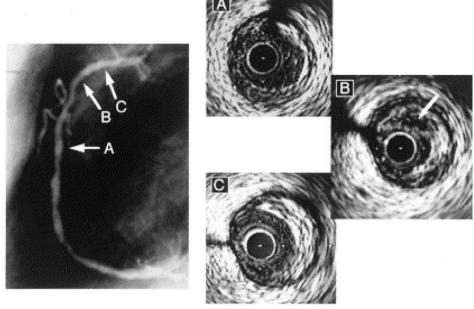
Coronary plaque in the right coronary artery (RCA) of a patient presenting with an acute coronary syndrome as evaluated by coronary angiography (left) and intravascular ultrasound (right). (A) A mild concentric lesion at the distal part of the RCA. (B) In the proximal portion a significant eccentric lesion with an echolucent area (arrow) and high plaque burden of 67%. (C) More proximally an eccentric lesion with high echo density. Reprinted with permission from Yamagishi et al.¹⁹
